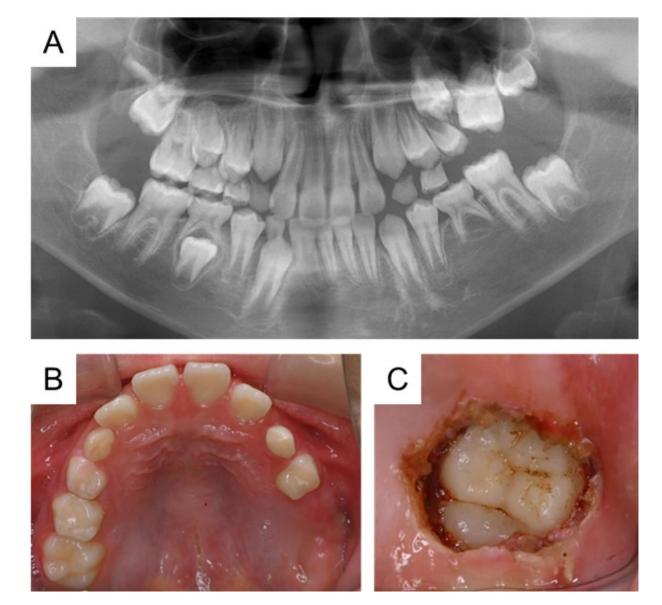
Fenestration of the first molar at 8 years 10 months of age. (A) Panoramic radiograph. Intraoral photographs before (B) and after (C) surgical exposure.
